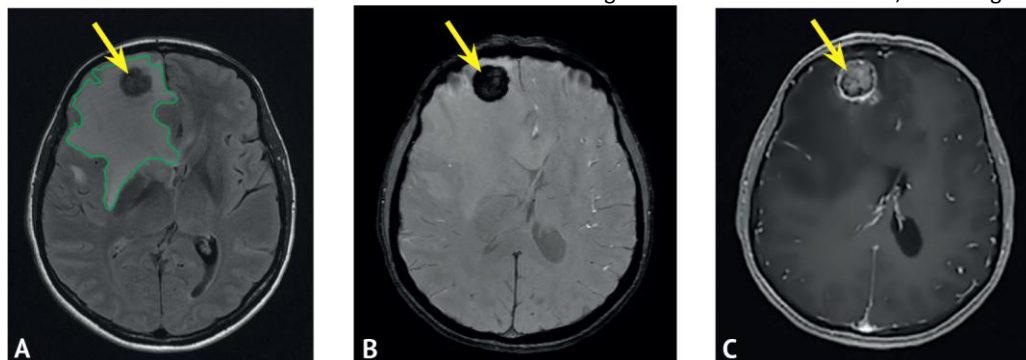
Results of control magnetic resonance imaging performed 6 months after stereotactic radiosurgical treatment: A - axial projection in FLAIR mode; B - axial projection in SWAN mode; C - axial projection in T1 FSPGR mode with intravenous contrast enhancement. There is a change in the structure of the meningioma (arrow) to a more heterogeneous one, with a fuzzy outline and diffuse hemosiderosis according to the SWAN mode. In the perifocal substance of the right frontal lobe, there is a zone of significant edema (circled by a green line). With intravenous contrast enhancement, the accumulation of a contrast agent is noted not only in the tumor, but also in the substance of the right frontal lobe (a sign of a violation of the integrity of the blood-brain barrier)
